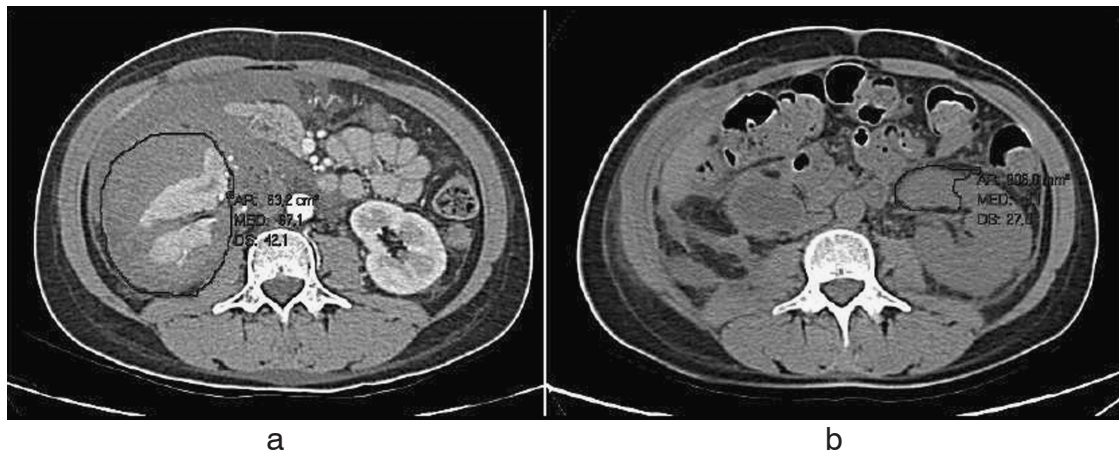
a. CT scan of the abdomen and pelvis showed a severe right renal capsular bleeding with a voluminous haematoma (20 cm). b. CT abdomen showed a left renal laceration with a vast haemorrhage.
